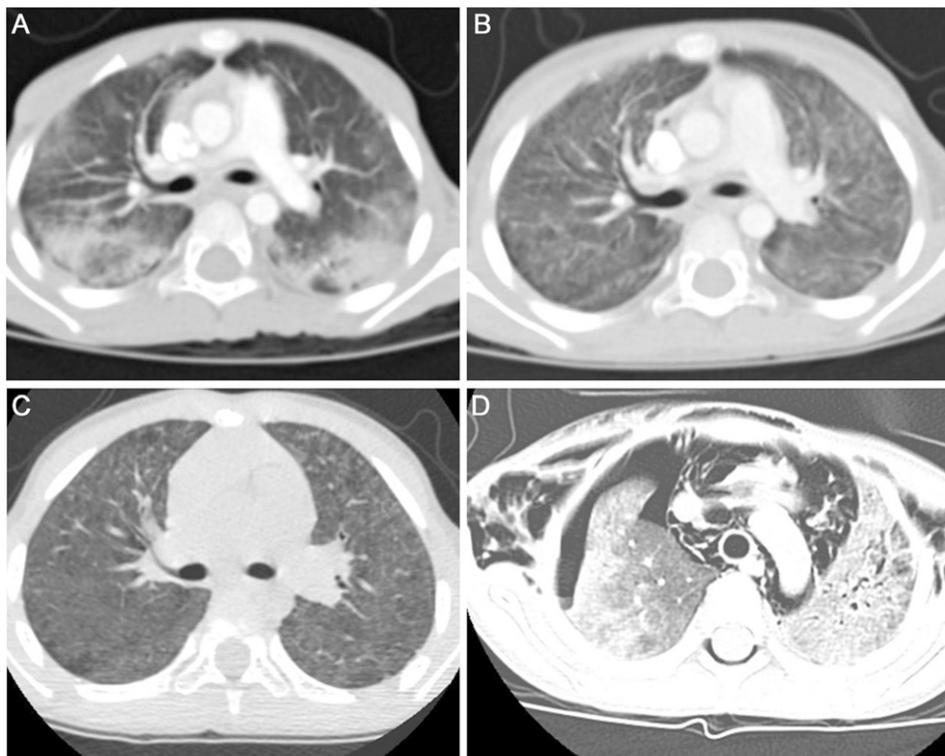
Radiologic findings of representative cases of humidifier disinfectant-associated children's interstitial lung disease. (A) Chest computed tomography (CT) performed 3 weeks after symptom onset showed multifocal patchy consolidation and peribronchial infiltration with subpleural sparing. (B) After 1 month of follow-up, the chest CT scan showed diffuse centrilobular ground-glass attenuation with the disappearance of the consolidation. (C) Chest CT of the patient after 1 year showed diffuse centrilobular nodules with ground-glass opacities, which are consistent with diffuse centrilobular fibrosis. (D) In a 5-year-old girl with a severe disease course, the chest CT scan showed extensive pneumomediastinum, pneumothorax, and subcutaneous emphysema.
